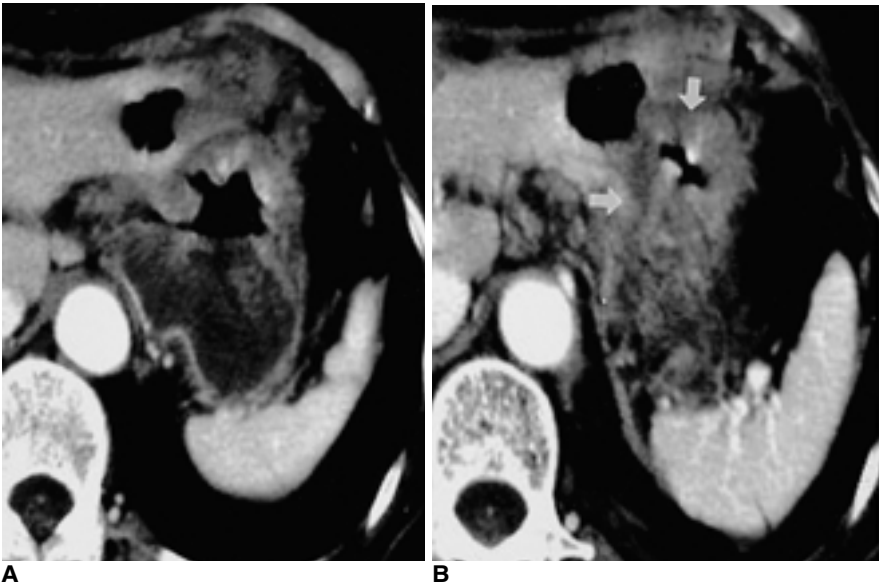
Sequential CT scans show the the wall thickening and stenosis at the gastrojejunostomy site (arrow in B). Note the slightly distended remnant stomach.
